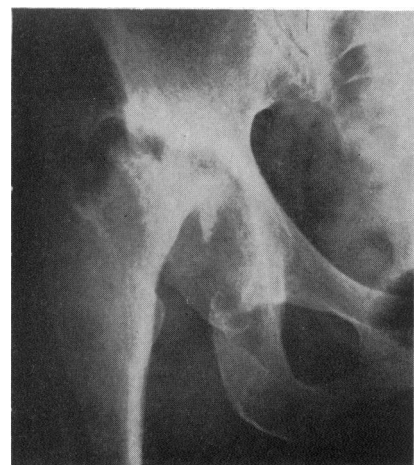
Radiograph of right hip after 18 months' treatment. Note gross destruction of femoral head and roof of acetabulum.
